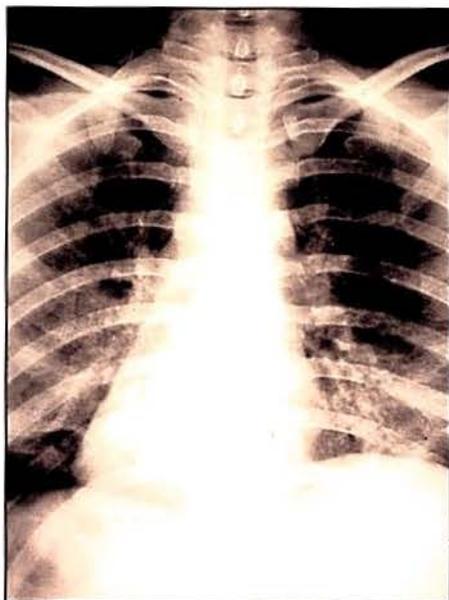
Chest x-ray demonstrating bilateral pulmonary infiltration.
